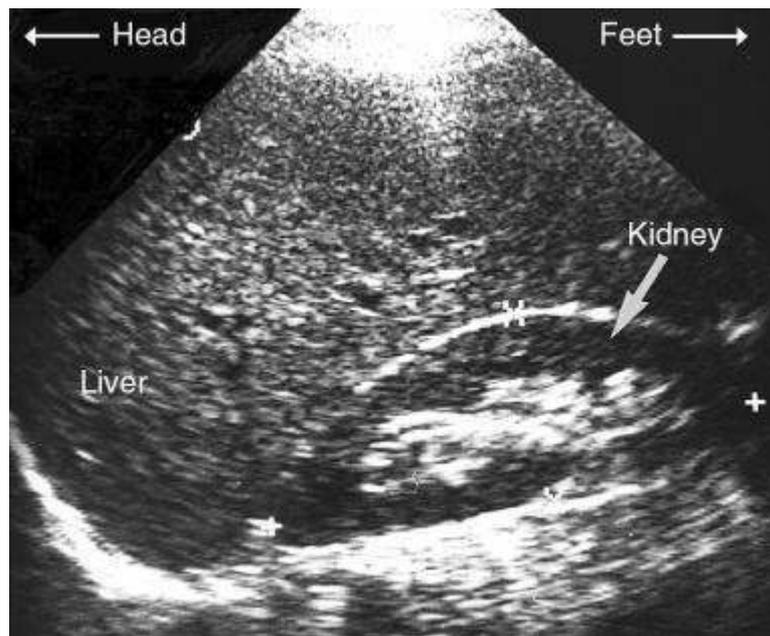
Ultrasound examination of the liver and kidney.
